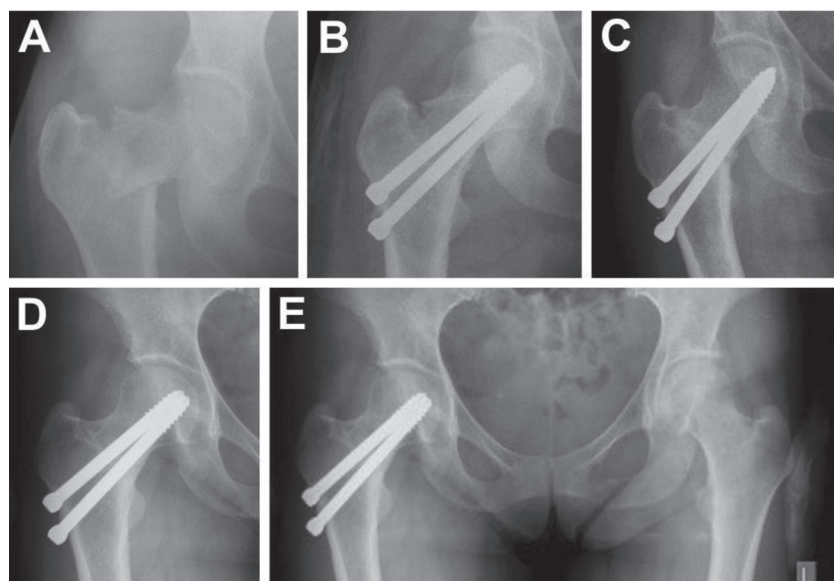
A 43-year-old female patient with unstable vertical (Pauwel III) intra-capsular femoral neck fractures, when Adam's arch is missing and lateral cortex suffers the greatest load, in our series of patients treated with two self-tapping antirotational fixations screws – serial follow up X-ray (A – initial; B – 12 weeks postoperative; C – six months; D – 12 months; E – 24 months postoperative)
